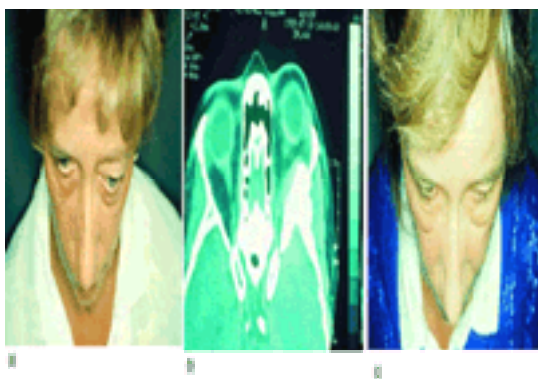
(a) A patient presenting with proptosis as a result of an intraosseous meningioma in the greater wing of the sphenoid. (b) An axial computed tomography scan through the orbits showing the tumour in the bone and the adjacent soft tissues of the orbit and meninges. (c) The patient's proptosis corrected by removal of the tumour.
